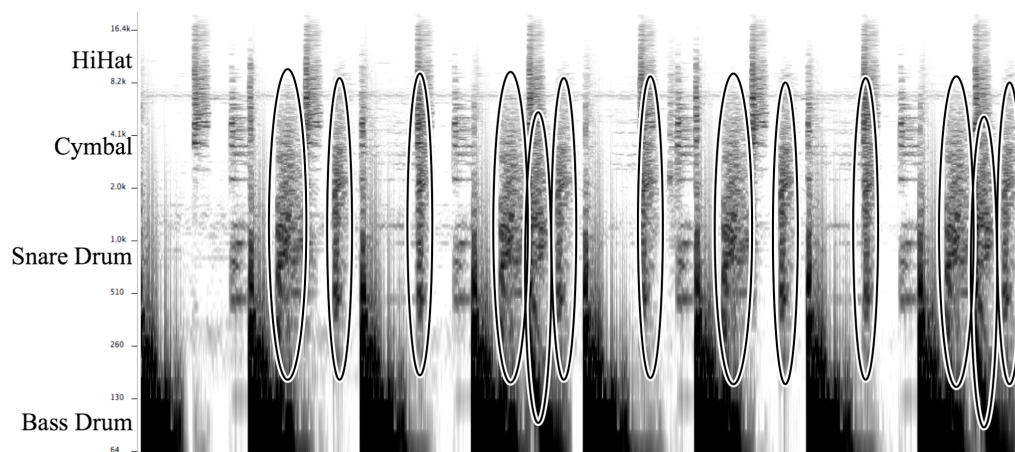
Sonogram of Basement Jaxx’s *Jump n’ Shout*, 0:18–0:21, snare drum sounds circled.
